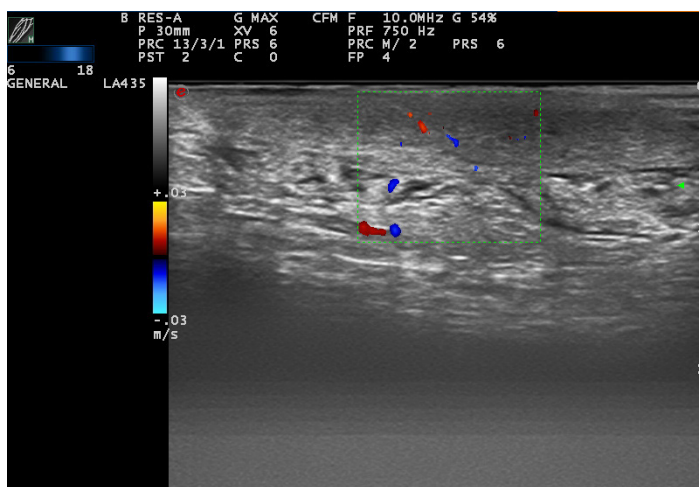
Cutaneous ultrasonography (linear probe 10-18 MHz): diffuse hypoechogenicity and increased dermal thickness with a diffusely elevated color Doppler. The presence of fistulas or abscesses was rejected.
